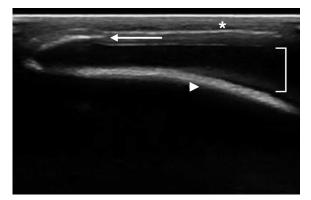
Point-of-care ultrasonographic image demonstrating the skin (asterisk) and skull cortex (arrowhead) with a disruption in the cortex of the skull, with step deformity (arrow) and hematoma (bracket).
